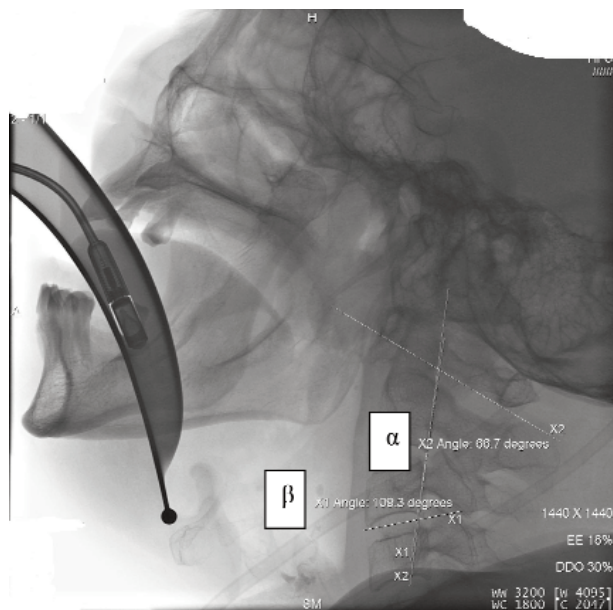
Lateral cervical spine radiograph: Lateral cervical spine radiograph: maximum cervical spine extension during intubation via the direct laryngoscopy.
